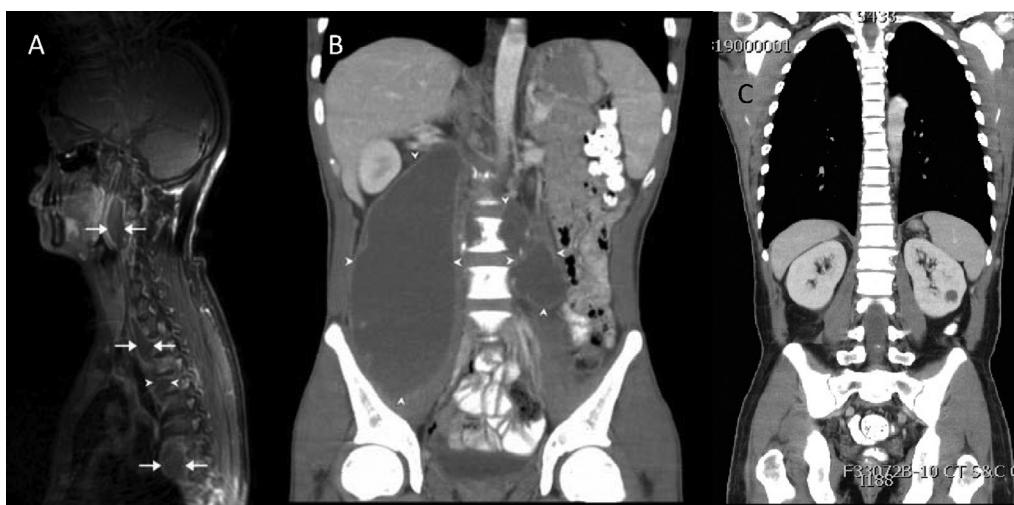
Imaging. (A) Magnetic resonance imaging confirmed vertebral spondylodiscitis (arrowhead), and retropharyngeal and multiple paraspinal thoracic abscesses (arrows); (B) Computed tomography scan revealed a large abscess measuring $8.5 \times 9.2 \times 20$ cm in the right iliopsoas muscle (arrowheads) and $4.0 \times 2.9 \times 5.4$ cm in the left iliopsoas muscle (arrowheads). (C) the computed tomography scan showed that the multiple tuberculous abscess had resolved after antituberculous drug therapy.
